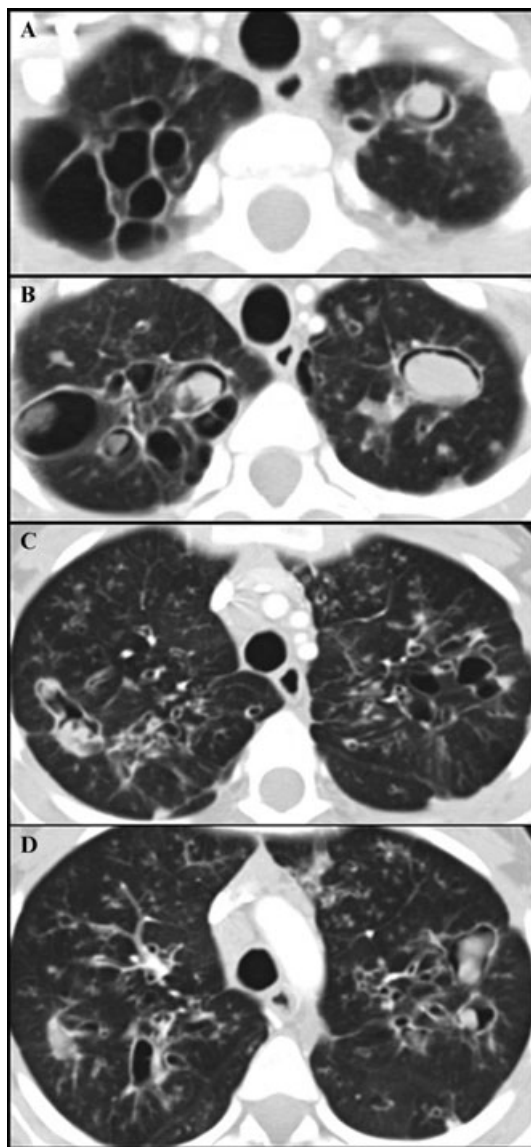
Patient 2. The figures above are images taken from a single CT scan at varying points in the upper lobes of this CF patient. (A) and (B) are two images in upper lobes of the lung, showing multiple thin-walled cavitations. Classic aspergilloma of clear halo and with no cavitation presents within the cavities bilaterally. (C) and (D) show widespread bronchiectasis and cavitation. In the right lung is a single cavity displaying two fungal balls, however this may also occur in a vertical plane. Eleven fungal balls were visualized by imaging.
